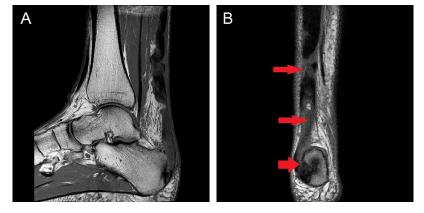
(A) Lateral T1 magnetic resonance imaging scan showing avulsion and distal and proximal ruptures in the watershed region with central calcification. (B) Coronal magnetic resonance imaging scan showing same findings seen on lateral view and mid-substance calcification.
